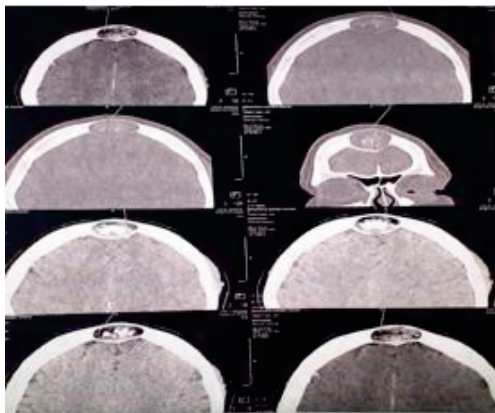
cerebral CT-scanner showed an osteolytic lesion blowing the internal and external tables.
